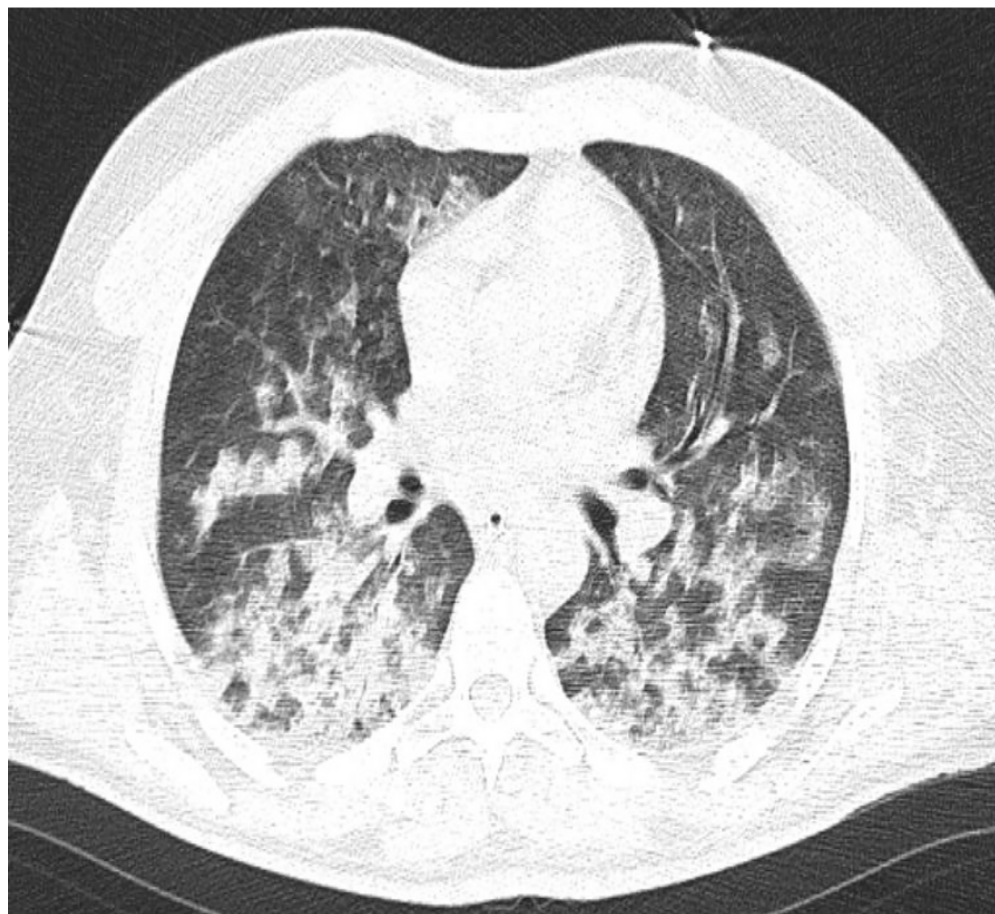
Chest high-resolution computed tomography (HRCT), without contrast, in an inspiration period, showed interlobular septal thickening and bronchiectasis in both lungs more prominent in bilateral upper lobes.
